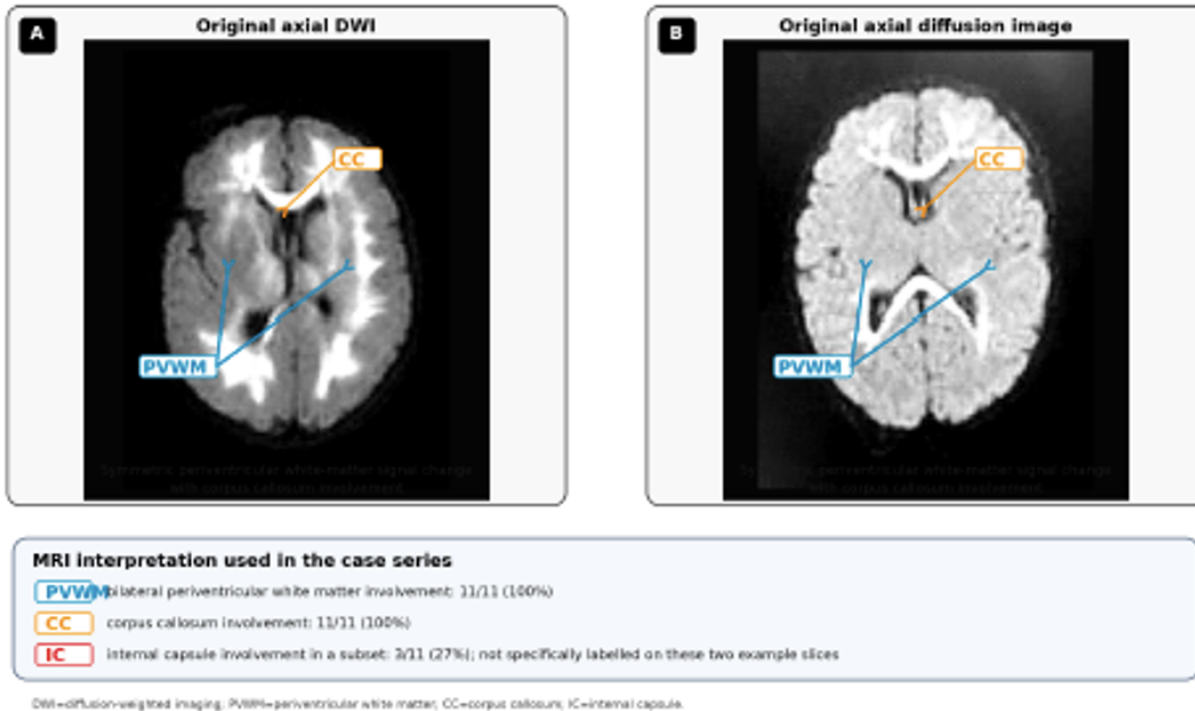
Original axial MRI diffusion images demonstrating the cohort-defining white-matter pattern. Panel A shows an anonymised original axial diffusion-weighted MRI image with bilateral symmetric signal change in the periventricular white matter and midline callosal region. Panel B shows a second anonymised original axial diffusion image at a comparable level, again demonstrating the same symmetric periventricular-callosal distribution. The coloured annotations identify the key anatomic regions used for interpretation: PVWM (blue) and CC (orange). Across the cohort, PVWM and corpus callosum involvement was present in all 11 infants (100%), while internal capsule involvement was present in 3 of 11 infants (27%). ADC maps were reviewed in the clinical MRI assessment to confirm true restricted diffusion, although the representative images shown here are diffusion panels. DWI=diffusion-weighted imaging; ADC=apparent diffusion coefficient; PVWM=periventricular white matter; CC=corpus callosum; IC=internal capsule.
